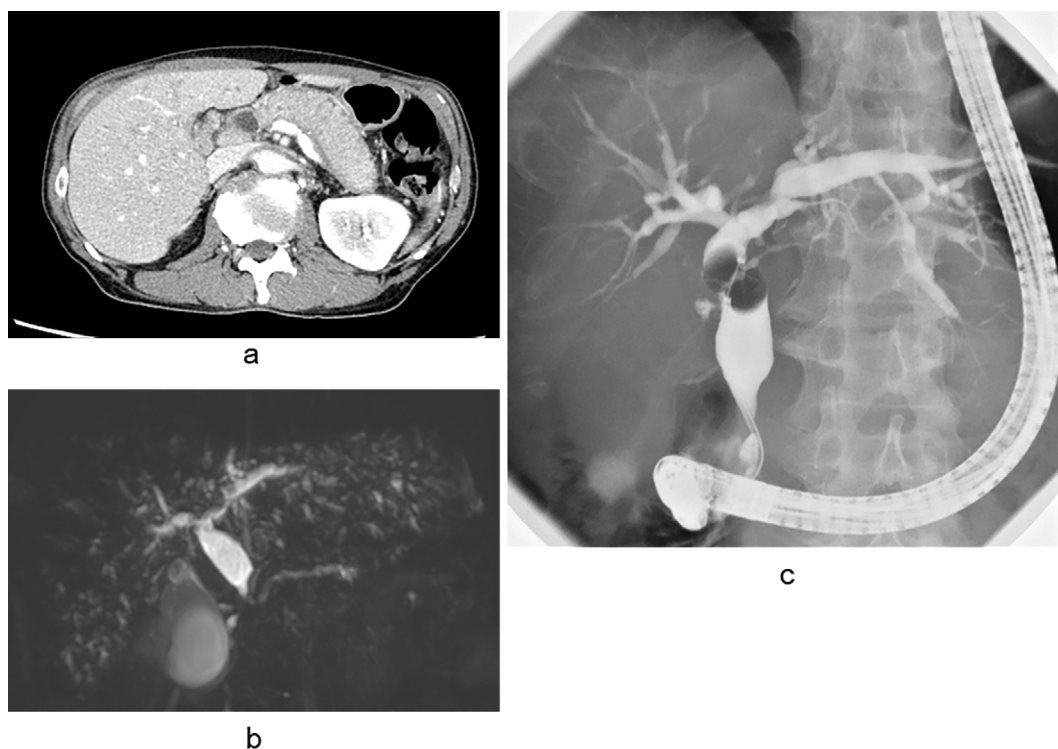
Images obtained at 8 months after tapering prednisolone treatment. (a) CT shows a bulky pancreas with a capsule-like rim without dilation of the pancreatic duct, as seen previously. (b) MRCP shows a distal stricture of the common bile duct with dilation of the hilar bile duct. In addition, the intrahepatic bile duct shows multiple strictures. (c) ERCP shows a distal stricture of the common bile duct with dilation of the hilar bile duct. Moreover, the intrahepatic bile duct shows multiple sclerotic changes with mild strictures.
